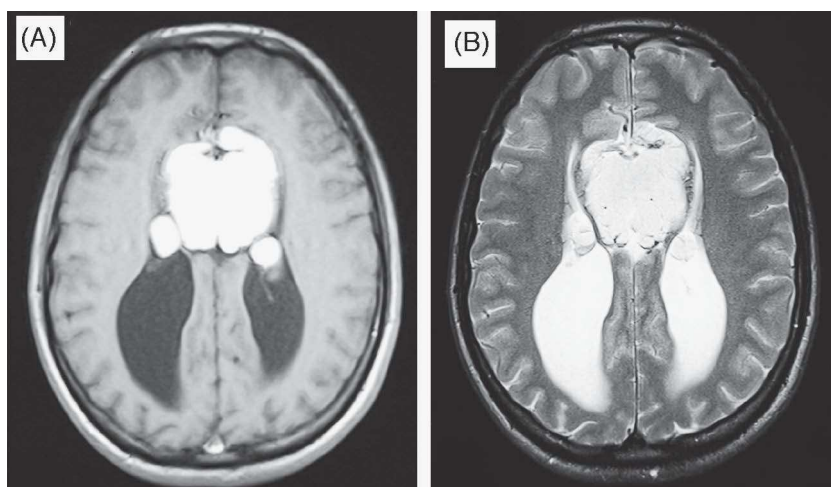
A: T1-weighted Magnetic resonance imaging (MRI) in the axial plane. B: T2-weighted MRI, in the axial plane.
